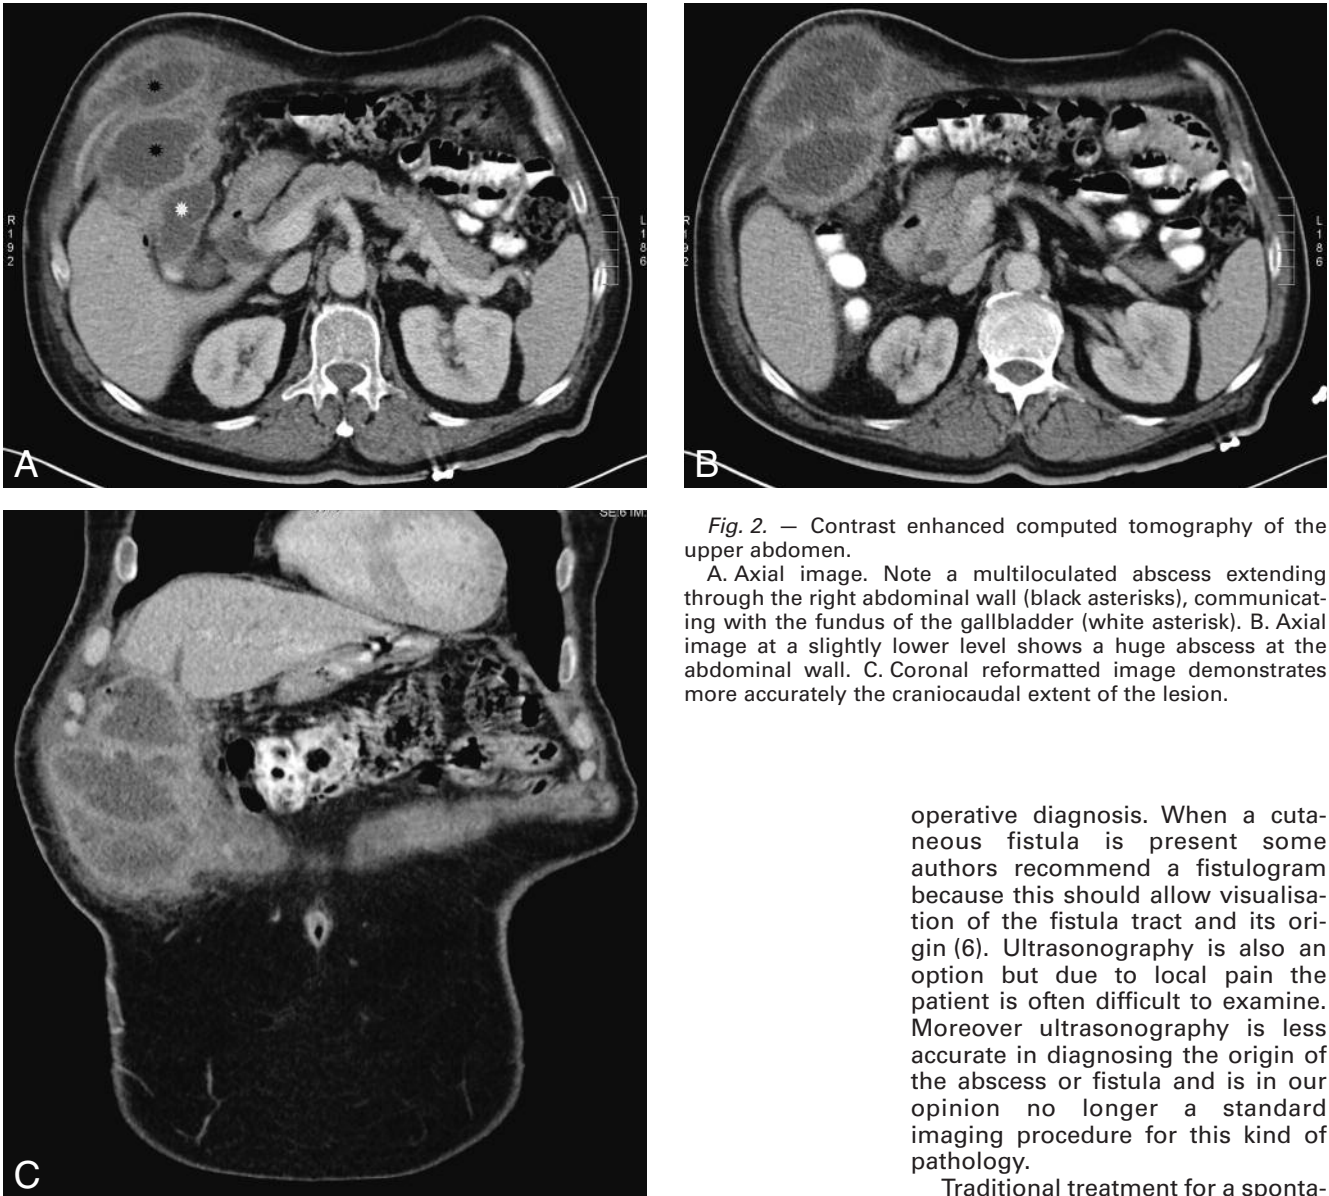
Contrast enhanced computed tomography of the upper abdomen.
